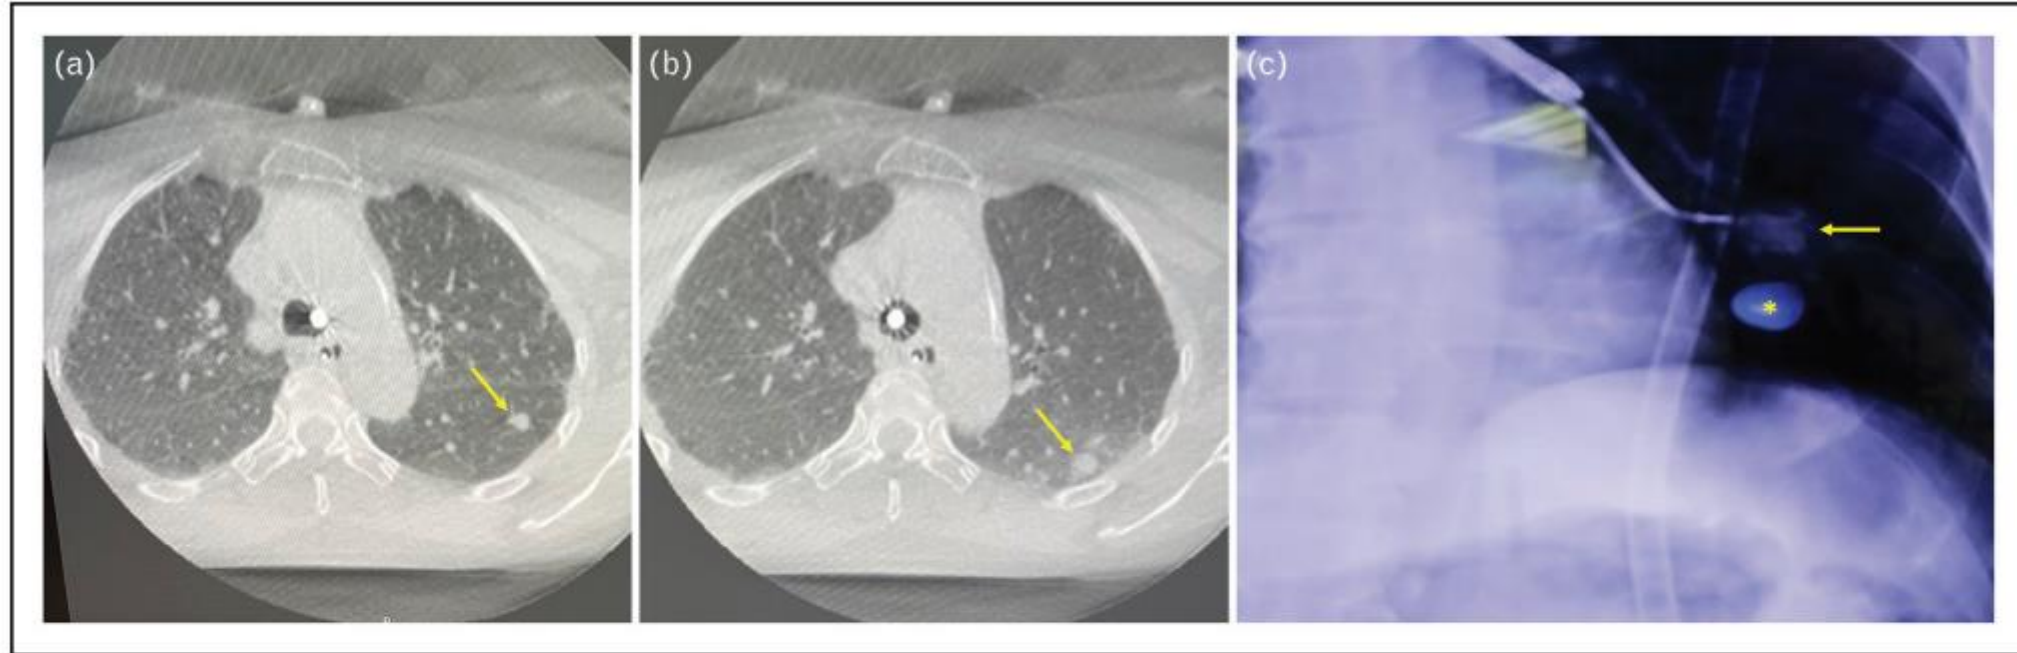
CT-body divergence. (a) Right lower lobe nodule (arrow) on cone beam CT imaging immediately after intubation. (b) Cone beam CT imaging after approximately 6 min of bronchoscopic navigation showed significant posterior displacement of the right lower lobe nodule (arrow) due to dependent atelectasis despite high-pressure ventilation to combat lung-derecruitment. (c) Augmented fluoroscopy demonstrating a radio-opaque target lesion (arrow) to be in a significantly different location as compared to where it was demarcated (asterisk) on cone beam CT images just a few minutes prior. *Images courtesy of Brian D. Shaller.*
